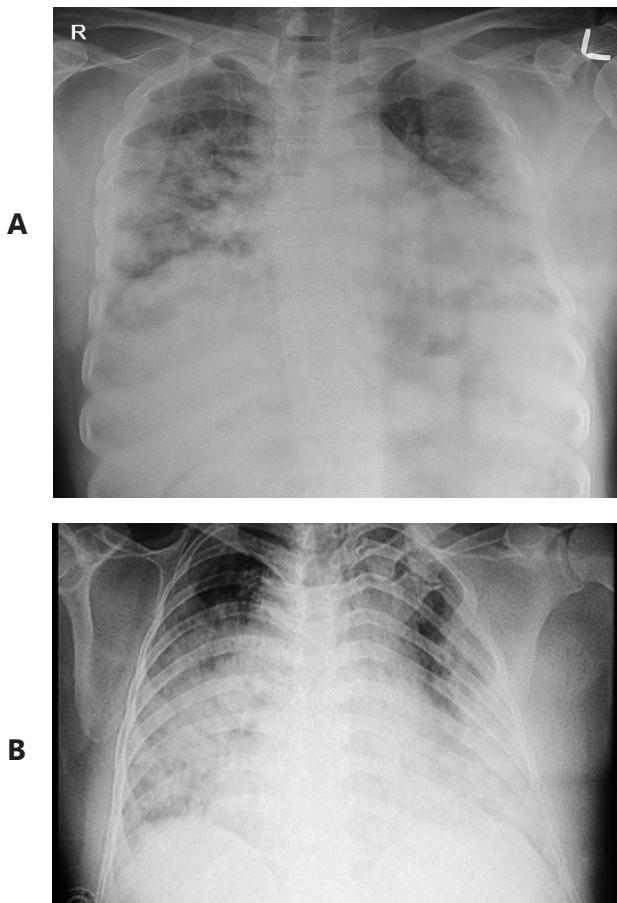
CXR findings of Covid -19 pneumonia: Posteroanterior chest radiograph shows bilateral peripheral and rounded lower and midzone zone opacities (A) and diffuse air space disease (B) in two different patients who has RT-PCR positive Covid -19 disease
